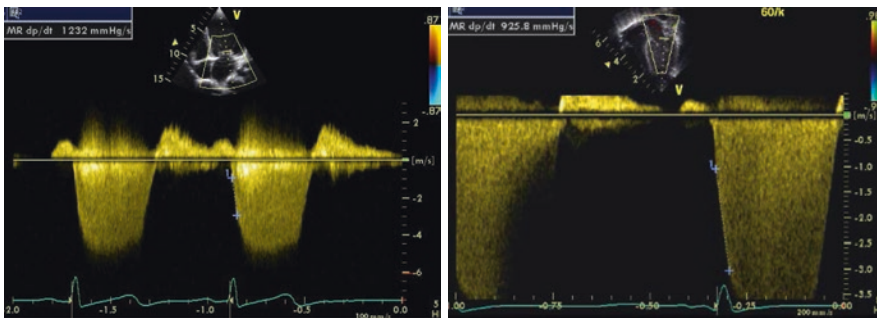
Doppler tracing from mitral regurgitation allowing measurement of the mitral regurgitation MR dP/dt max obtained between 1 and 3 m/s, on a normal patient (left image) and on a patient with left ventricular dysfunction
